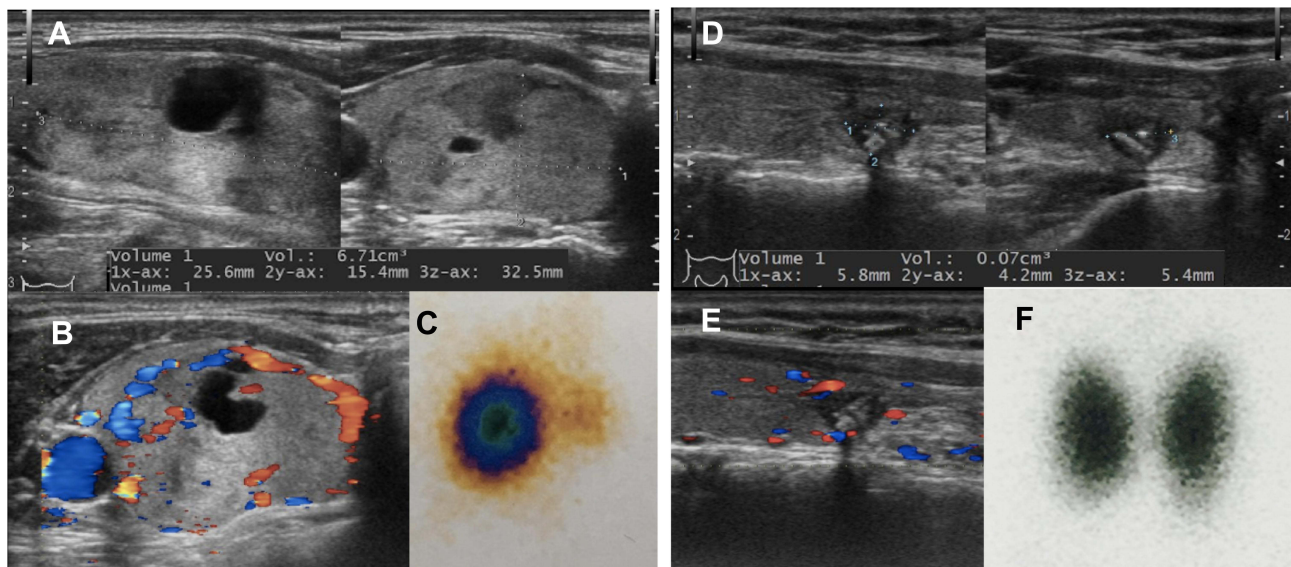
A 54-year-old woman presented with right neck bulging and hyperthyroidism symptoms who underwent radiofrequency ablation for AFTN treatment. (A) Initial volume of large thyroid nodule: 15x26x33mm, V~6.7mL. (B) Vascularity grade 2 in US. (C) At initial time, hot nodule presented in thyroid scintigraphy. (D) After 24 months ablation, VRR was 98%. (E) Vascularity grade 0. (F) Hot nodule was not totally detected in thyroid scintigraphy.
